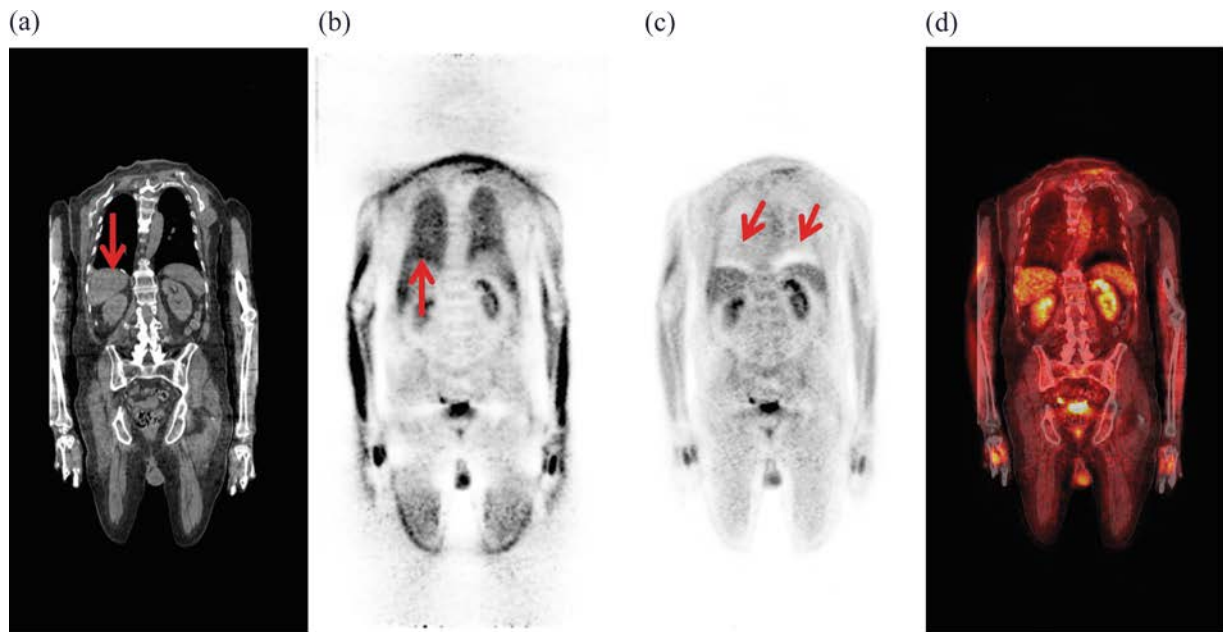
Coronal image planes of CT (a), noAC-PET (b), AC-PET (c) and fused AC-PET/CT (d) demonstrating local PET-CT misalignment of the diaphragm region resulting in photopenic areas above the diaphragm corresponding to undercorrection of attenuation in that area. This undercorrection is caused by the different caudo-cranial extent of the diaphragm on CT (a) and on the emission data (b). AC: attenuation corrected; noAC: not attenuation corrected.
